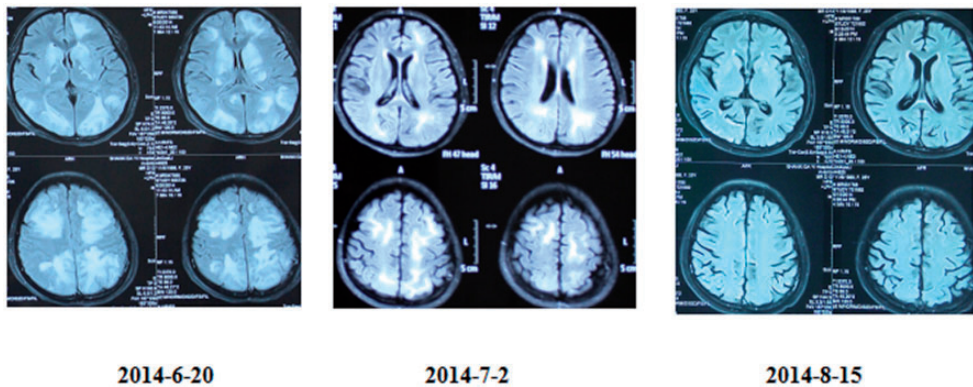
Comparison of magnetic resonance imaging results before and after treatment. a. fluid-attenuated inversion recovery (FLAIR) image obtained on 20 June 2014. b. FLAIR image obtained on 2 July 2014. c. FLAIR image obtained on 15 August 2014
